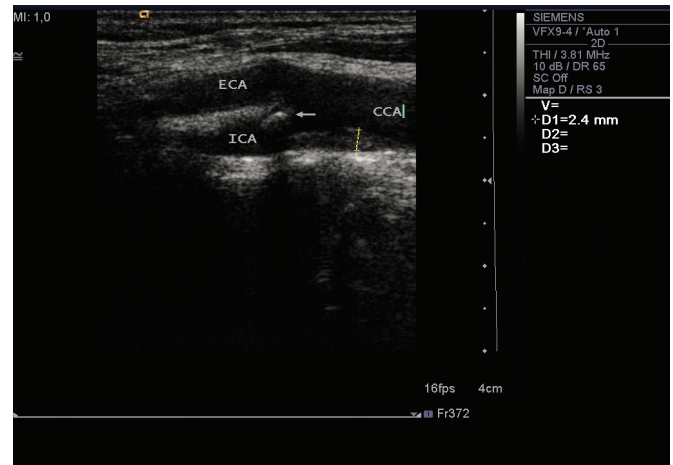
The intima-media thickness of a carotid artery as measured by B-mode ultrasonography. Dotted line indicates media-intima thickness. ECA indicates external carotid artery; ICA, internal carotid artery; CCA, common carotid artery.
